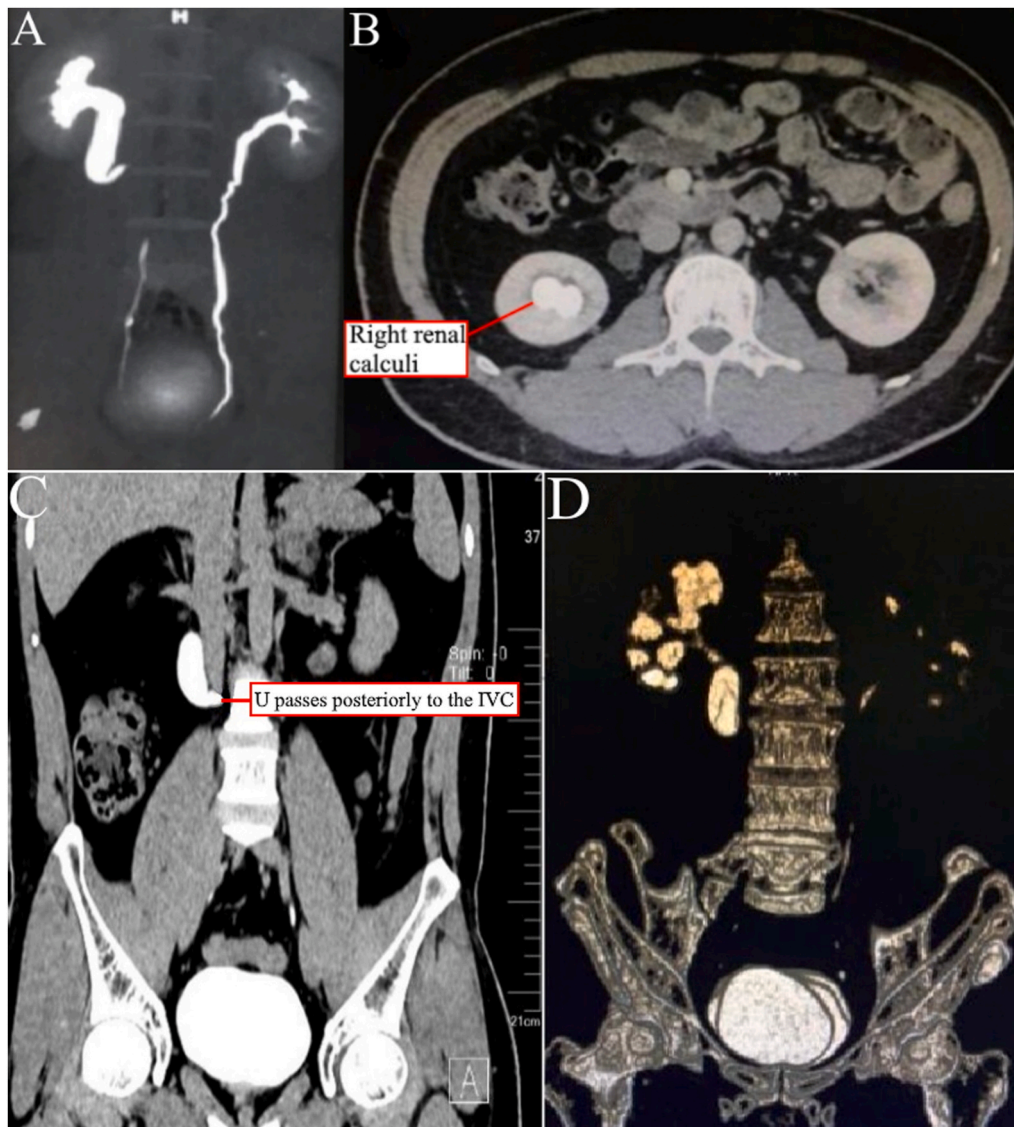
A. CTU scan B. CT scan C. CTU scan D. 3D model.
